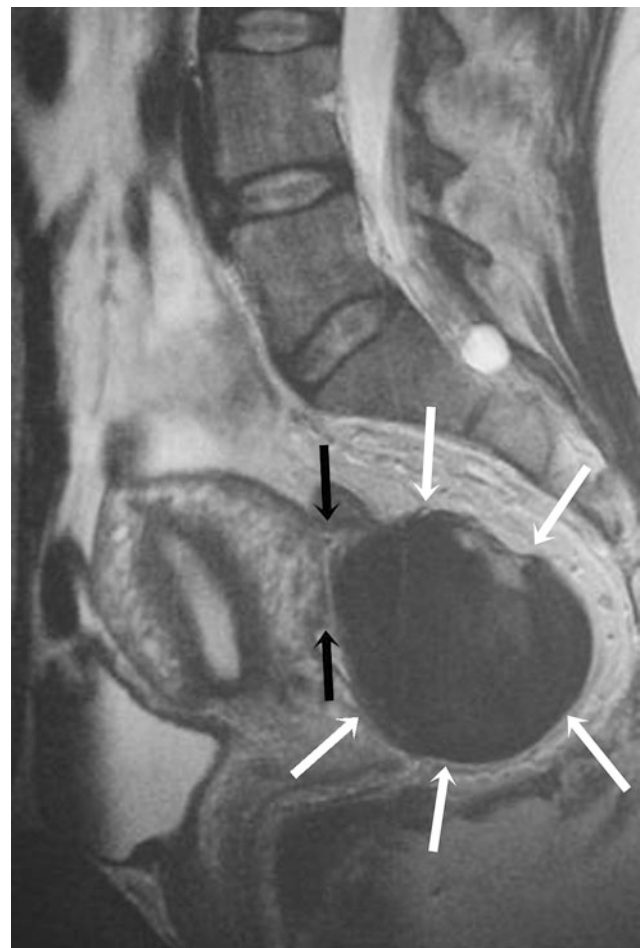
Narrow-based pedunculated serosal fibroid. Sagittal T2-weighted MR image of the pelvis with a posterior pedunculated serosal fibroid (*white arrows*). The narrow-based attachment is indicated by the *black arrows*
